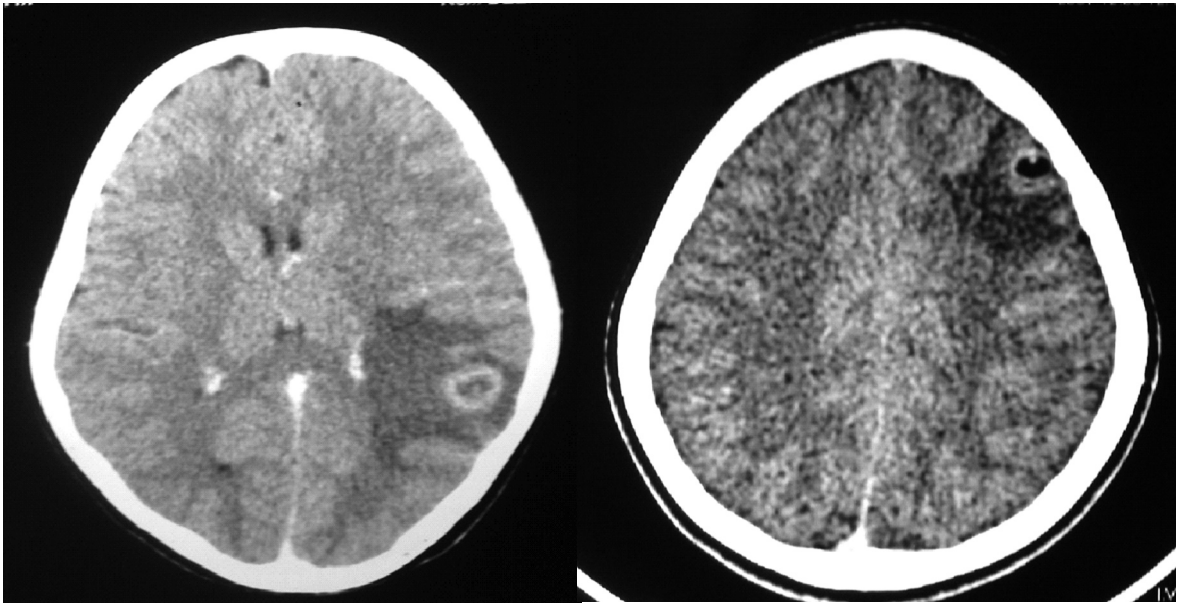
CT Scan : Ring enhancing lesion with scolex
